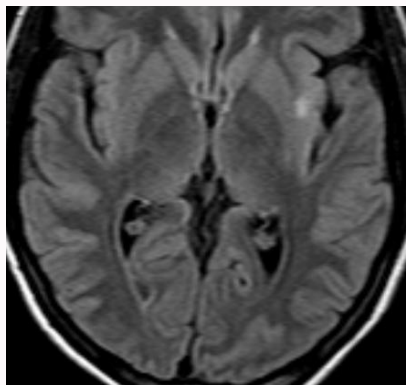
Brain axial FLAIR image.
